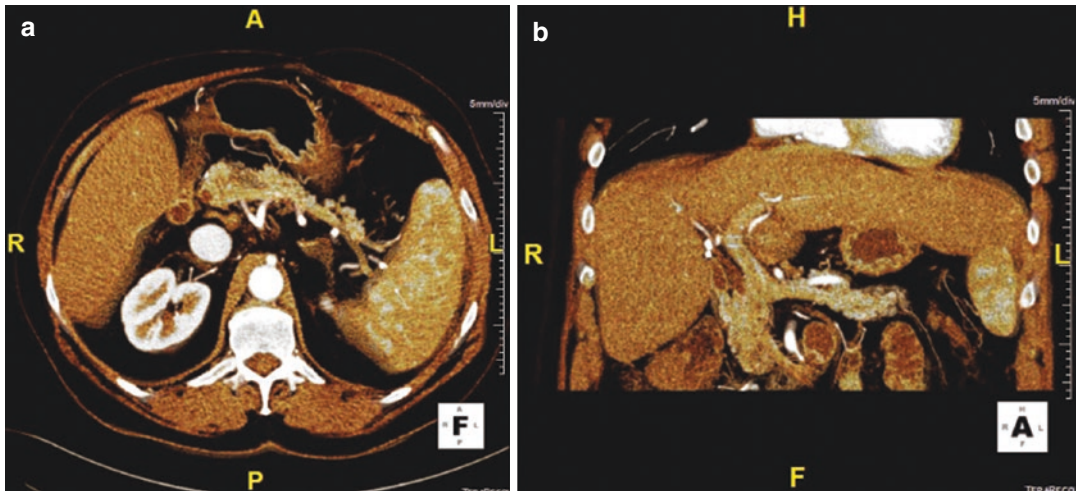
Using an independent advanced imaging workstation, 3D images can be created from CT data. Axial (a) and coronal (b) thick slab 3D reconstructions show the vascular structures with greater definition
